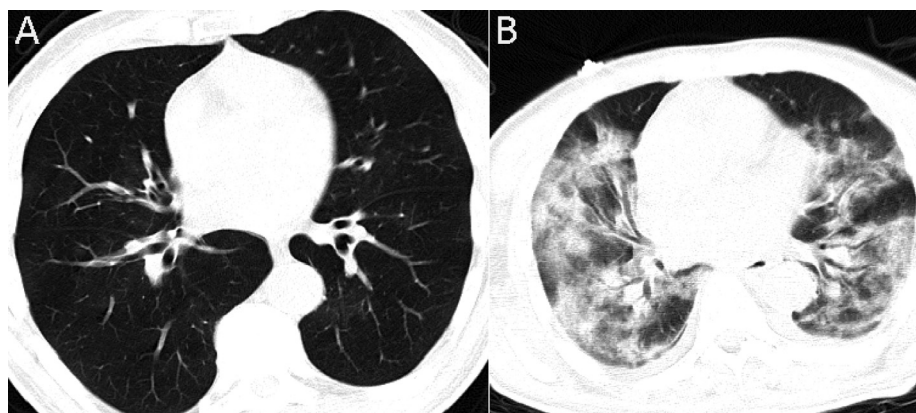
Chest computerized tomography (CT) scan of a 67 year old man (A) on admission day showing patchy ground glass opacities and (B) on the 17th day diffuse bilateral ground glass alveolar opacity casting the pulmonary lobules together with confluent areas of consolidation opacities and bilateral pleural effusion.
